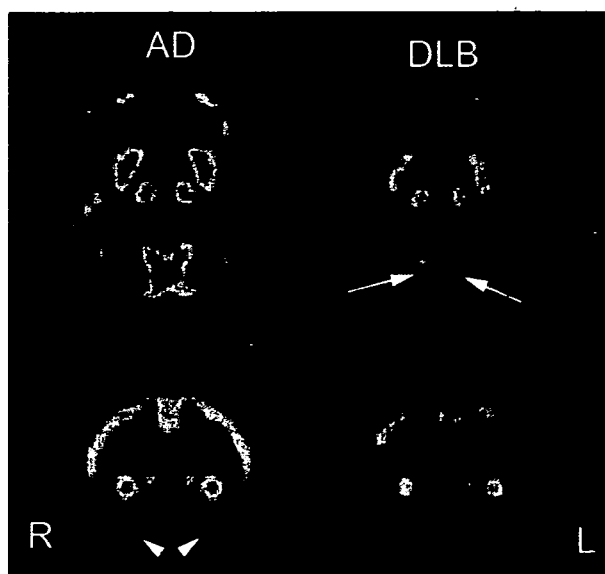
Comparison of brain perfusion SPECT images for moderate AD and moderate DLB. DLB showed lower perfusion in occipital cortex than AD (arrows). In contrast, AD showed lower perfusion in medial temporal areas (arrowheads).
